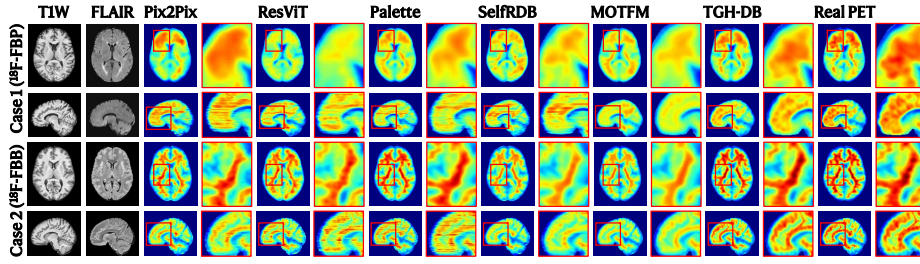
Examples of synthesis results, shown together with the input multimodal MRI scans and real PET images for reference. Note the red boxes for comparison.
